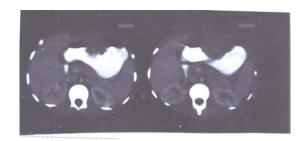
Abdominal CT with contrast showing T.B mass involving the greater curvature of the stomach.
